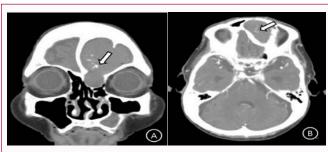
Coronal (A) and axial (B) enhanced computed tomography scan showing a large, expansile, heterogenous mass and the typical hyper attenuating fungus ball with calcific foci (arrow) in the left frontal sinus.
